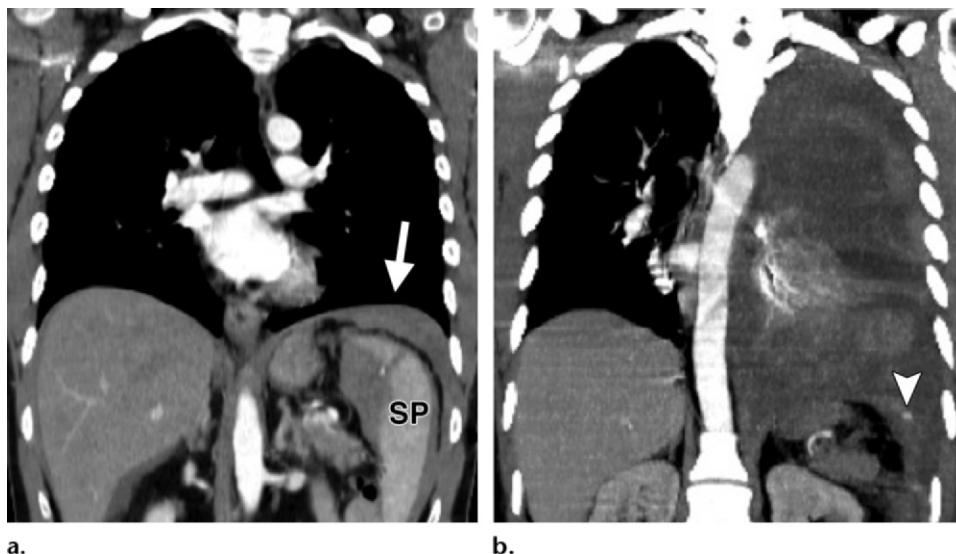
(a) Coronal contrast-enhanced reformatted CT image obtained in a 42-year-old man with blunt thoracoabdominal trauma from a motor vehicle accident shows diffuse thickening (arrow) of the left hemidiaphragm and laceration of the spleen (*SP*). (b) Coronal contrast-enhanced reformatted CT image obtained a few hours later, as a massive left hemothorax developed, shows a pool of extravasated contrast medium in contact with the diaphragm (arrowhead), a finding suggestive of BDR. At surgery, a lesion was found in a small branch of the superior diaphragmatic artery, with no evidence of BDR. The apparent diaphragmatic thickening in a was due to diffusion of a retroperitoneal hemorrhage. (Case courtesy of Mostafa El Hajjam, MD, Club Thorax, Paris, France.)
